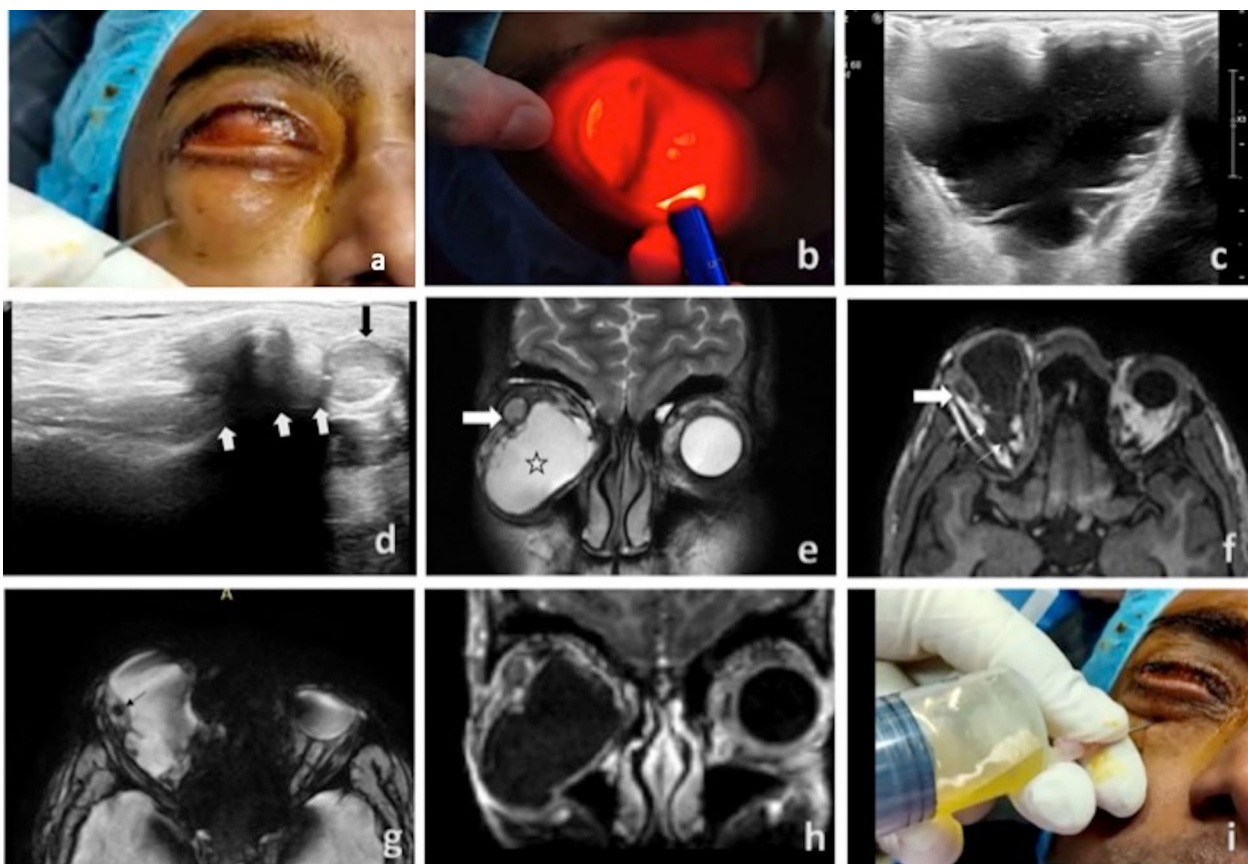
Case 3: On clinical examination (a, b), cystic right eye with positive transillumination was noted. B scan (c, d) demonstrated cystic cavity with lobulated margins, low level internal echoes and few thin partial septations. A small globe (black arrow) was seen in the periphery with optic nerve (bold white arrows) at its posterior aspect. MRI coronal STIR (e) images shows intraconal lobulated cystic lesion (star) in right orbit. Small globe (white bold arrows) can be seen in superolateral aspect of the right orbit. A thin optic nerve (thin white arrows) can be traced till the posterior aspect of right globe on Axial 3D FSPGR (f). A focus of blooming (black arrow) is seen within the microphthalmic globe on SWAN images (g) which likely represents calcified lens. Contrast-enhanced coronal FSPGR image (h) shows thin peripheral wall enhancement of the cyst and globe. Cyst aspiration (i) revealed clear serous contents
